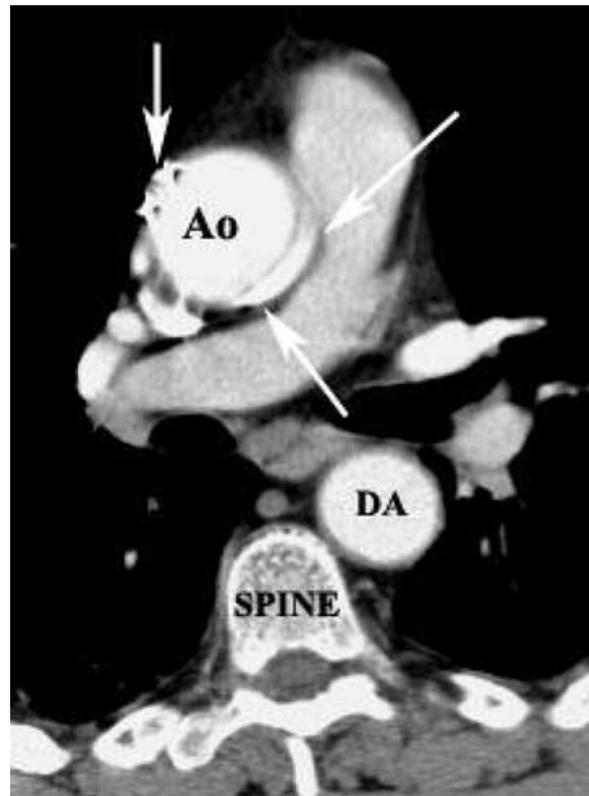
Transverse plane CT image with contrast demonstrates a crescent-shaped intimal hematoma (oblique arrows) within the wall of the ascending aorta (Ao). A surgical marker (vertical arrow) at the site of insertion of a vein graft is noted. DA, Descending aorta.
